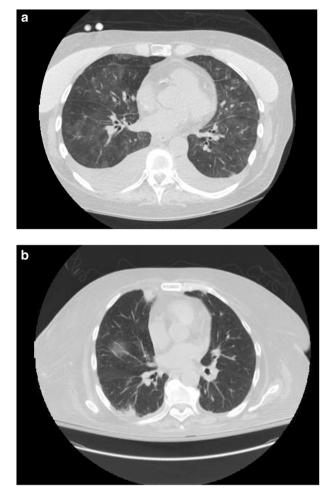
a A representative CT scan of a patient infected with coronavirus (HCoV) who progressed to proven lower respiratory tract infection (LRTI) without co-infection with a secondary respiratory virus. The CT demonstrates diffuse ground glass opacities, interlobular septal thickening in the airways and bilateral pleural effusions. b A representative CT scan of another patient infected with coronavirus (HCoV) who progressed to a proven lower respiratory tract infection (LRTI). The scan demonstrates focal areas of consolidation with air bronchograms and left lingular and left lower lobe ground glass opacities
